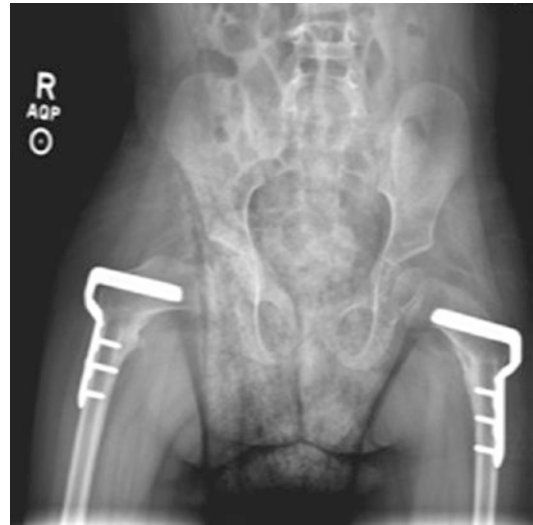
1-year postoperative radiograph demonstrates bilateral varus derotational osteotomies with improved coverage of both hips
